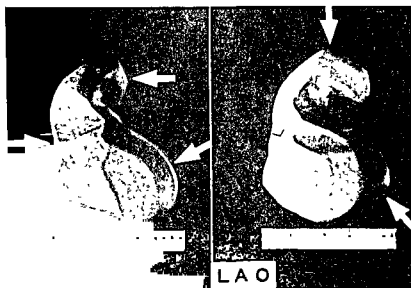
Old man. Hypertensive and atherosclerotic cardiovascular disease. Roentgenologic, volumetric reconstruction. *Ant view*: marked enlargement of lt ventricle caudad and to lt (lt lower arrow). Caudal shift of intersection between rt vascular and cardiac border (rt arrow), caused by enlargement of ascending aorta. Distal portion of arch (lt upper arrow). *Lt ant obl view*: prominence of lt ventricle dorsad (lt arrow). Enlargement and wide swing of aortic arch (upper arrow). Courtesy Prof Dr G G Palmieri, Bologna, Italy.
